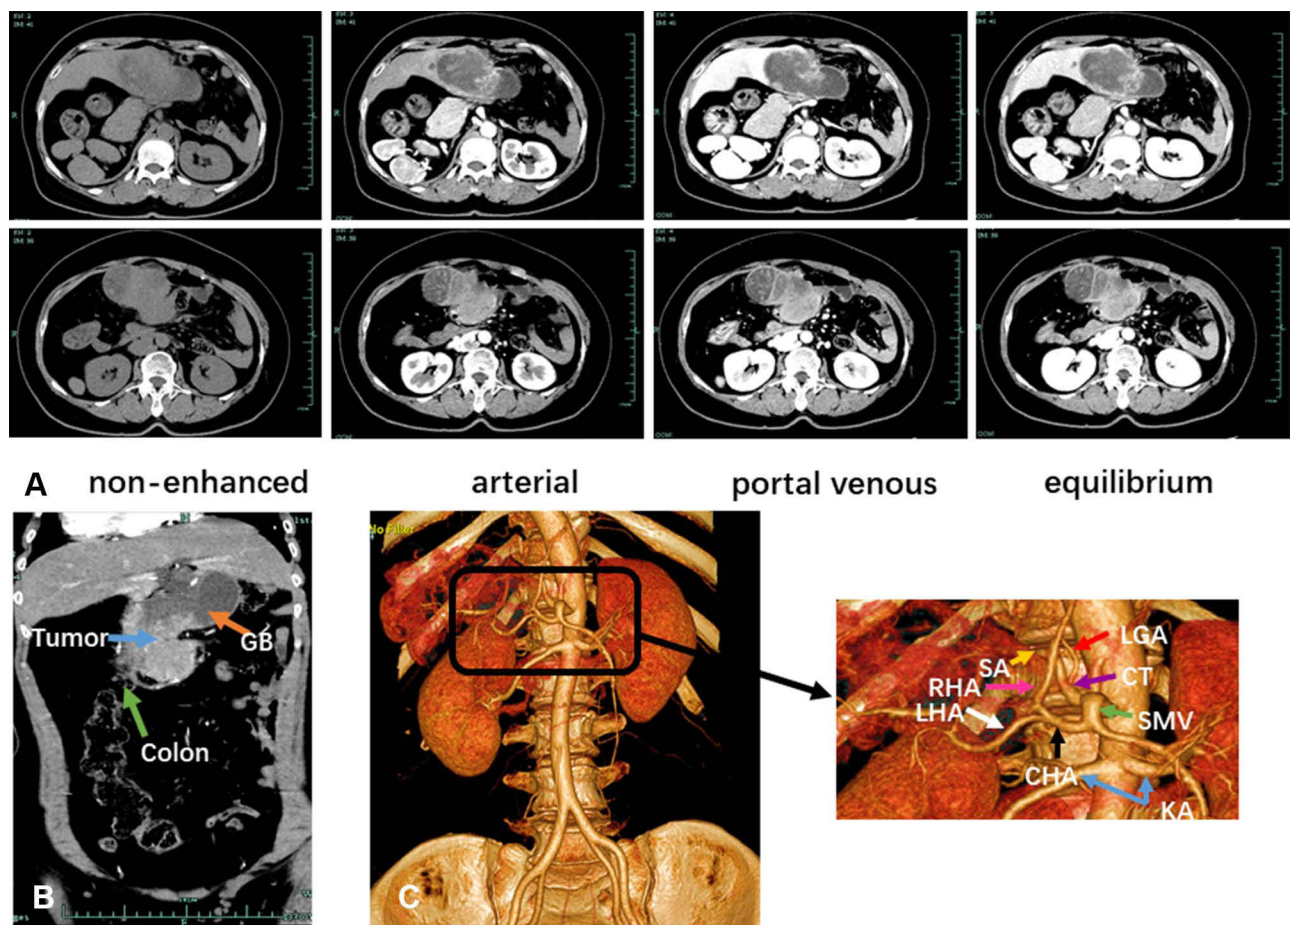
Preoperative CT scan indicated the diagnosis of gallbladder cancer in the SIT setting. (A) The CT images in the non-enhanced, arterial, portal venous, and equilibrium phases. (B) The coronal view showing tumor's involvement of transverse colon. (C) The CT angiography demonstrating significant vascular abnormalities. Abbreviations: GB, gallbladder; SMA, superior mesenteric artery; CT, celiac trunk; CHA, common hepatic artery; LGA, left gastric artery; SA, splenic artery; RHA, right hepatic artery; LHA, left hepatic artery; RA, renal artery.
